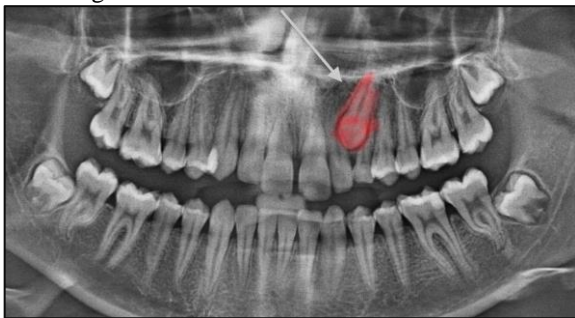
Radiographic image of unerupted tooth.
